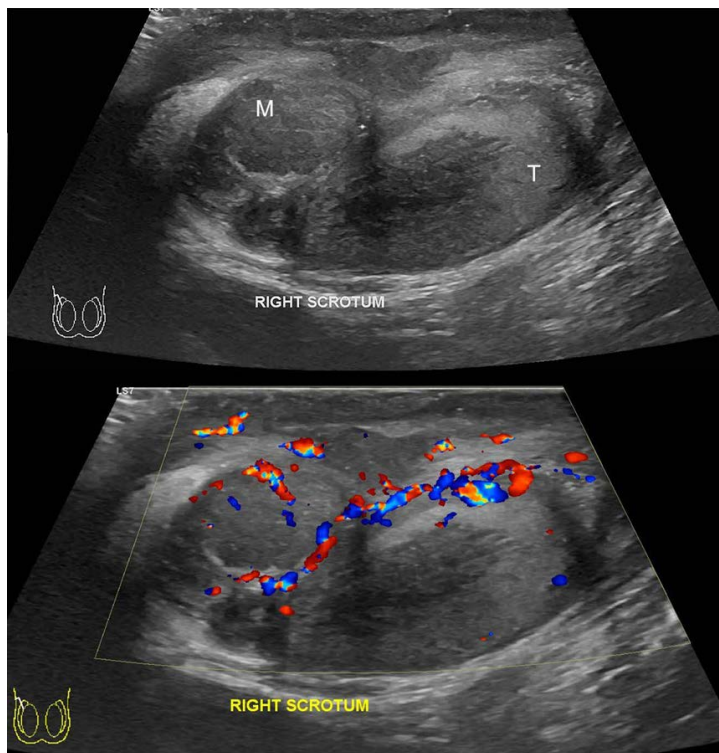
Ultrasound image of the patient’s right scrotum at the initial presentation. An ill-defined hypoechoic mass (M), predominantly which extra testicular, is seen as inseparable from the right testis (T). Colour Doppler image demonstrated increased vascularity of the mass lesion
